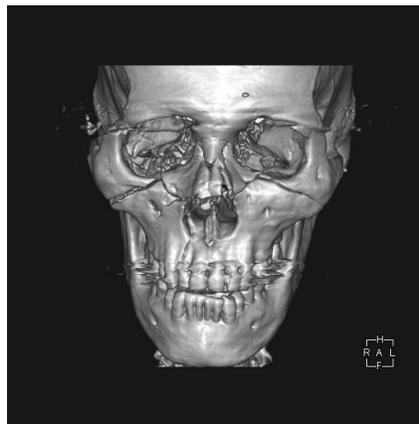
3D reconstruction of CT showing orbital wall fractures
